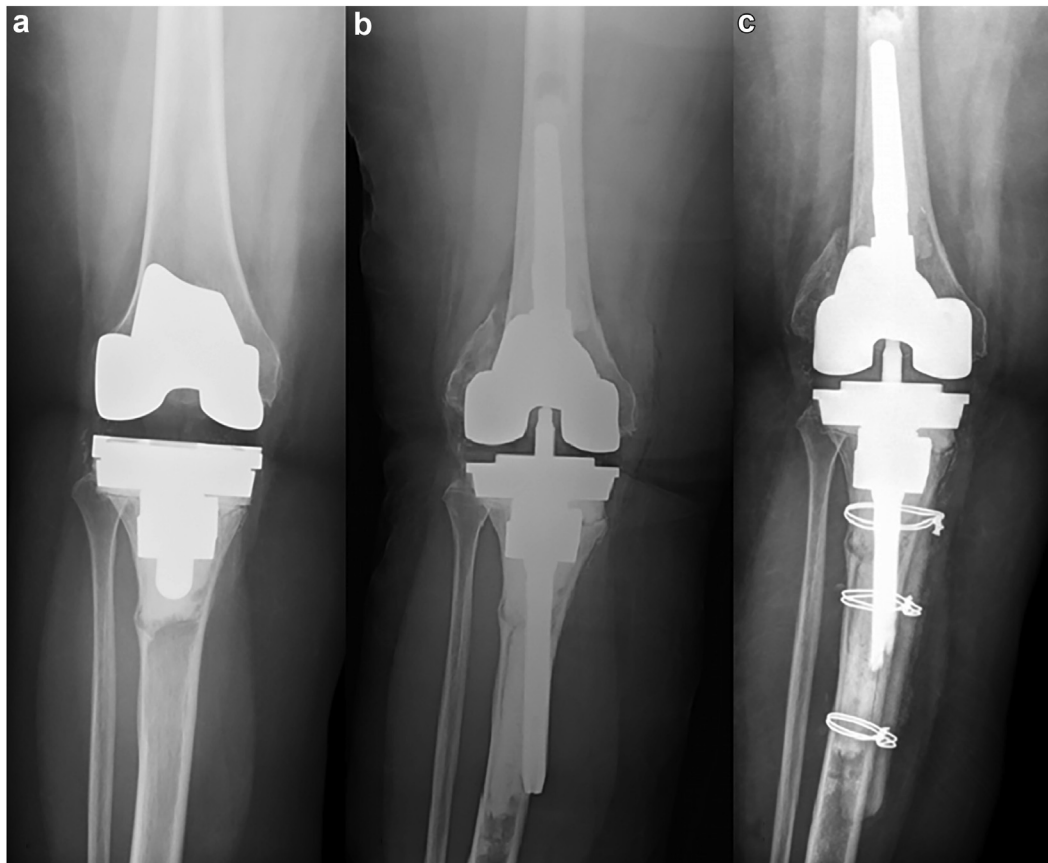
(a) Preoperative AP radiograph; (b) immediate postoperative AP radiograph after revision with tibial cone retention; and (c) a postoperative radiograph after re-revision for the symptomatic protruding tibial stem. The tibial cone was well-fixed and retained during the procedure.
